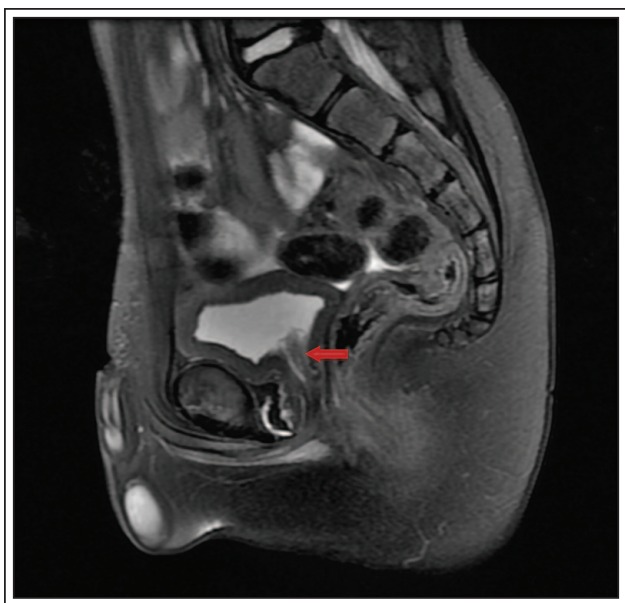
MRI T2 weighted sagittal view of a broad based posterior urethral lesion (red arrow) in our patient extending from the verumontanum into the bladder neck.
